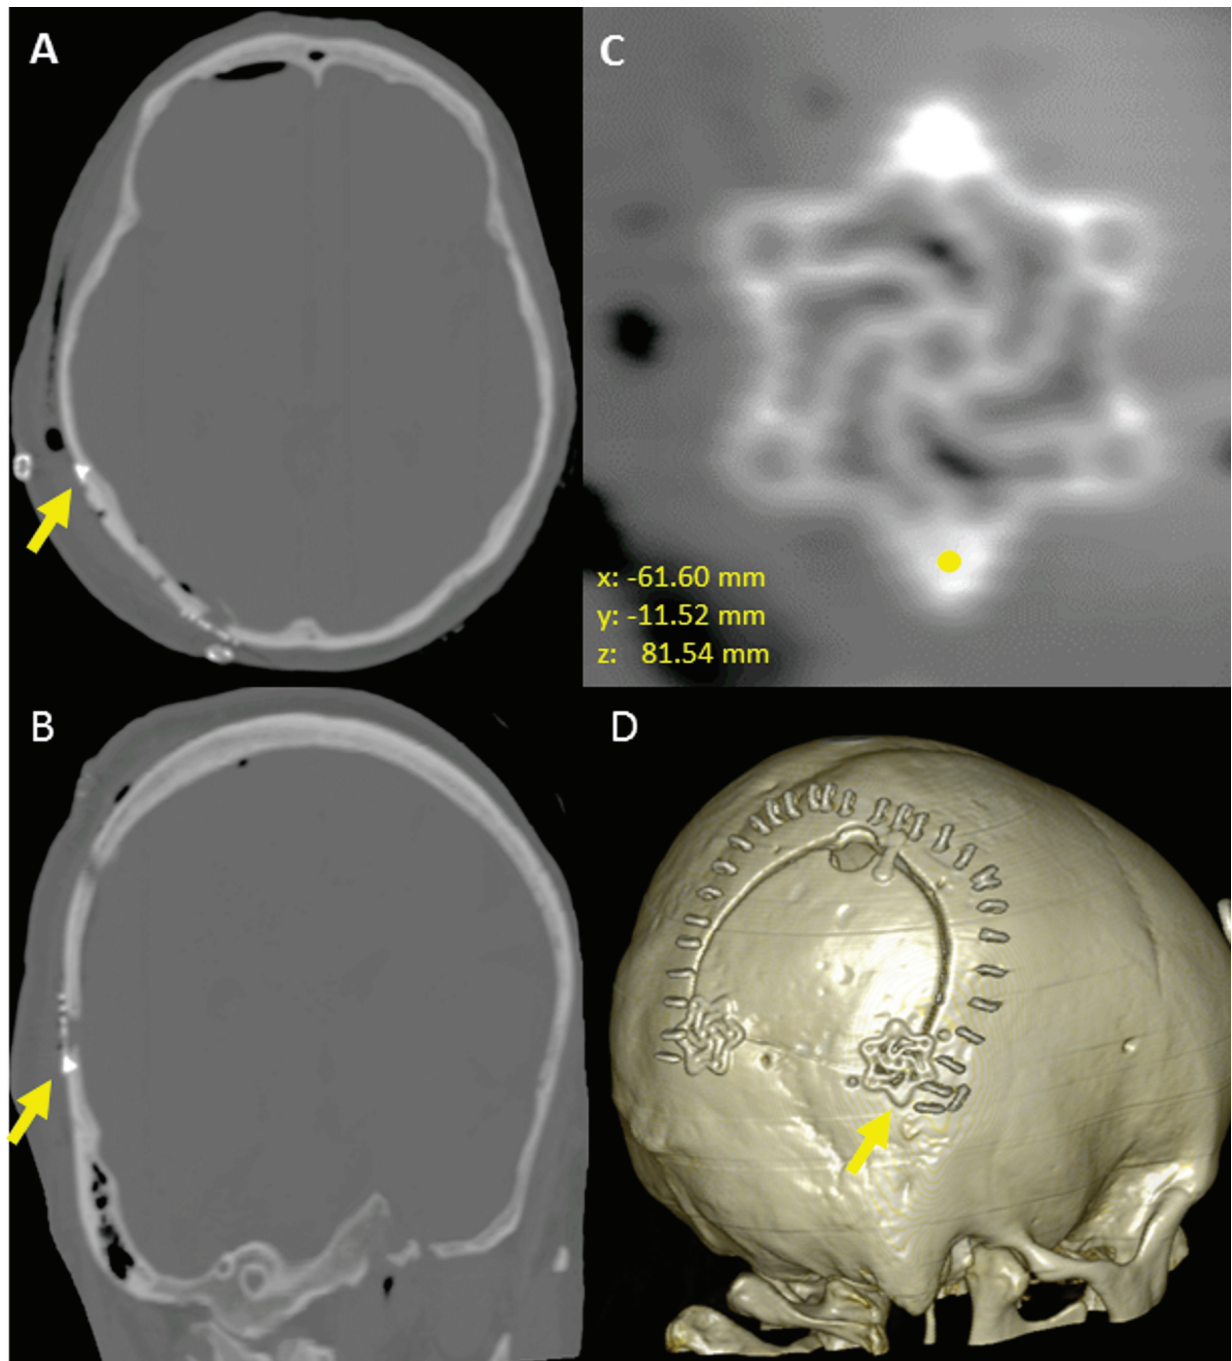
Engineering analysis quantifying cranial translational error. Comparison of postoperative cranial screw co-ordinates to intraoperative co-ordinates base on the location of the tracked probe. A) Axial CT representation, B) Coronal CT representation C) Multiplanar reformatted CT image (2 cranial fixation screws), (D) 3-dimensional volume rendered CT.
